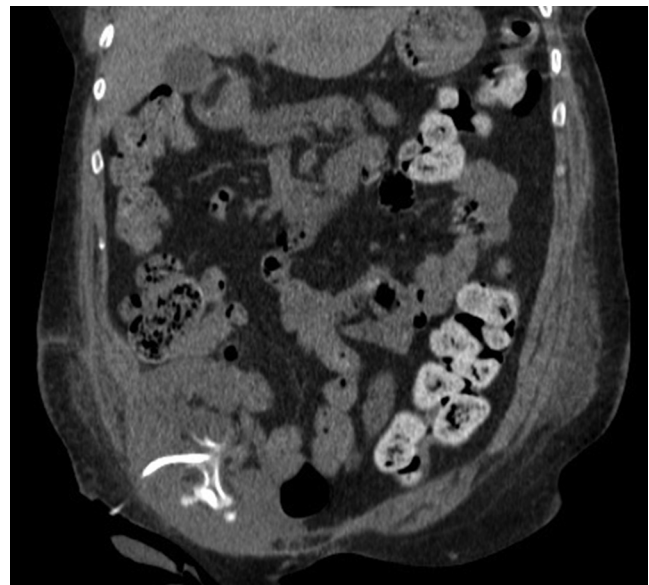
Computed tomographic scan prior to treatment demonstrating a nephrostomy tube *in situ*, with a thin layer of calcification involving the calyces, renal pelvis, and proximal ureter in the transplant kidney.
